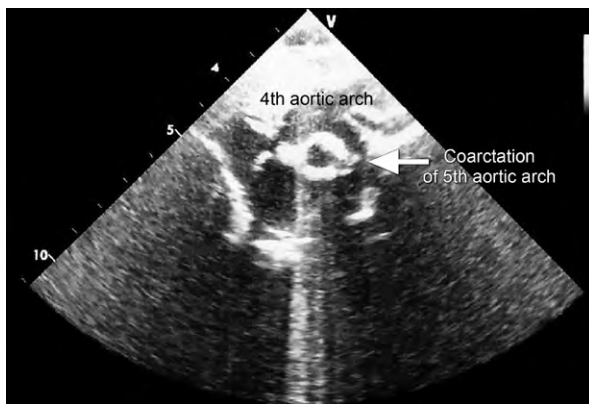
Echocardiogram shows left ventricular hypertrophy and a double-lumen aortic arch with coarctation at its inferior part.
